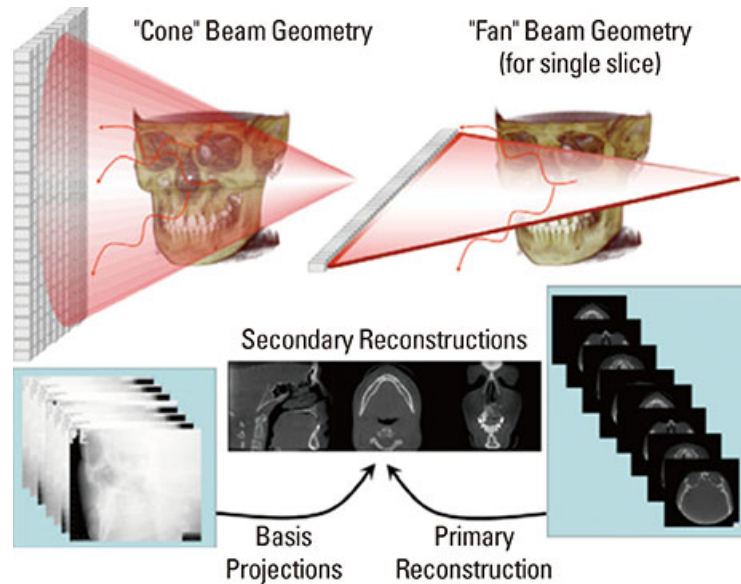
Data acquisition comparison between the conventional or “fan” beam (right) and “cone” beam (left) imaging geometry and resultant image production. (Courtesy: Scarfe WC, Farman AG. “What is cone beam CT and how does it work?”. Dent Clin North Am, 52(4),707-30, 2008)
